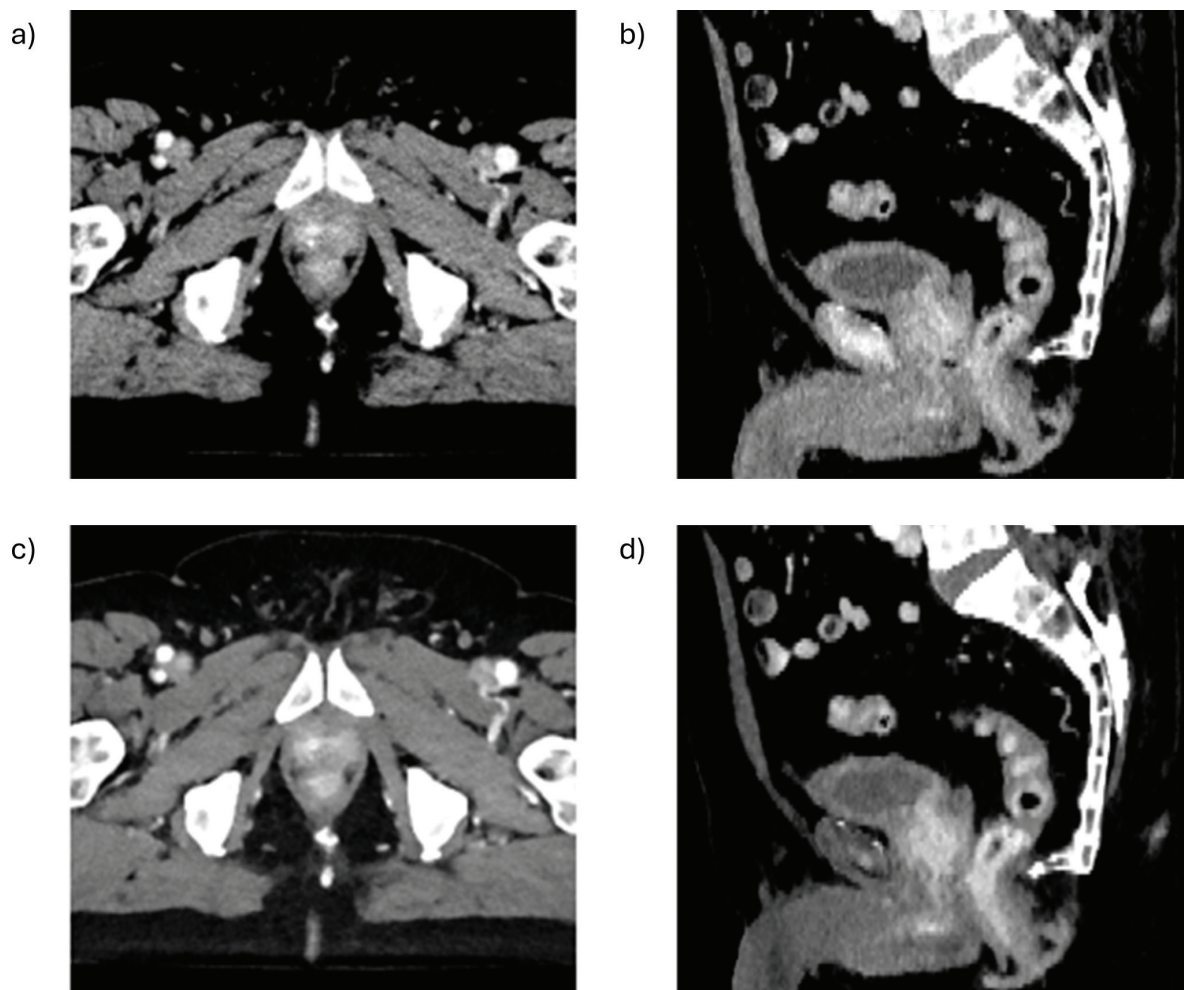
Comparison of two reconstruction parameter settings for patient 4. Axial views (a, c) are positioned just above the most caudally placed gold marker, and sagittal views (b, d) are centered on the prostate and bladder. (a–b) The 70 keV VMI with the Qr40 reconstruction kernel, which closely resembles the conventional SECT scan used as the standard for these patients. (c–d) The 40 keV VMI with the Br36 reconstruction kernel, identified as the preferred parameters. The window level settings were adjusted to achieve approximately equal contrast across the images, so the primary visible difference is the relative level of image noise. VMI: virtual monoenergetic image; SECT: single-energy computed tomography.
